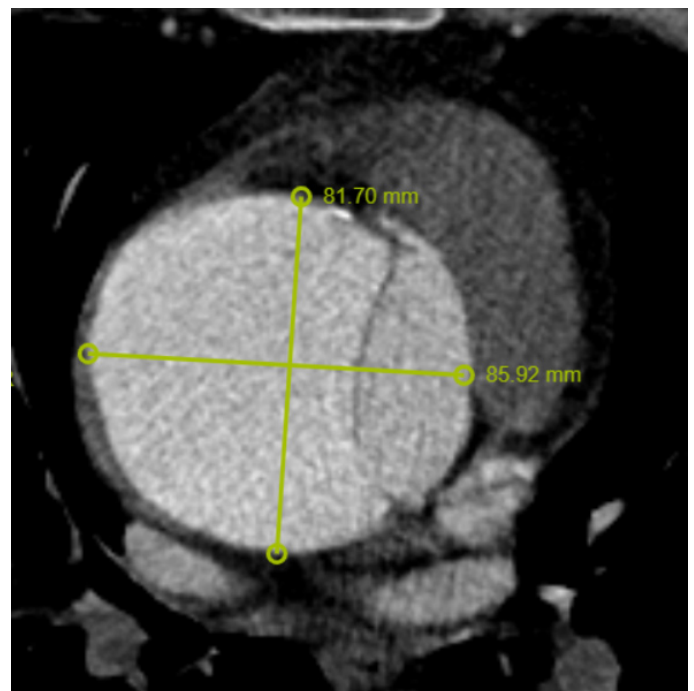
CT shows 80–81 mm aneurysm and Type A dissection line in the ascending aorta.
